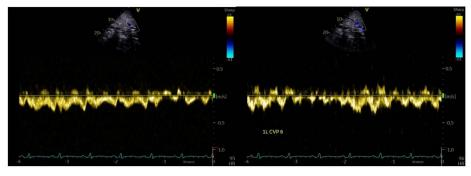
(Left) ECMO 3.4L flow baseline. (Right) ECMO 1L flow continues to show normal hepatic vein Doppler suggesting no congestion or RV failure.
